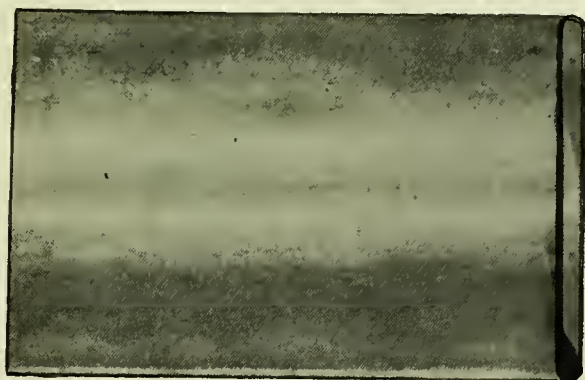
X-Ray Shield for Arm.
